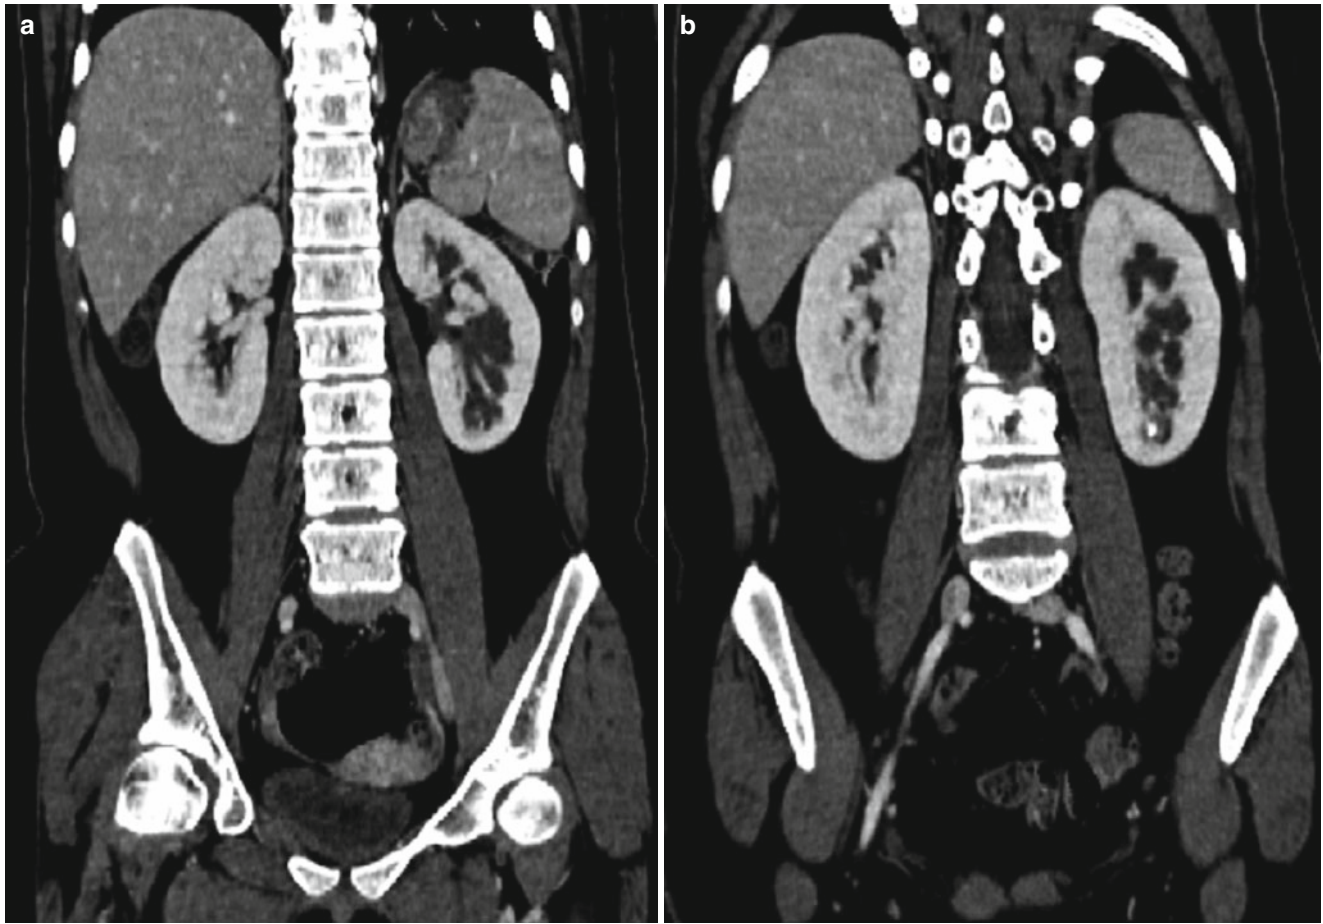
Congenital megacalycosis in a 15-year-old boy. (a and b) Contrast-enhanced CT scan with coronal reformat images show diffusely dilated calyces of left kidney without renal pelvic dilatation. There is a calyceal stone in left kidney lower pole (b)*
